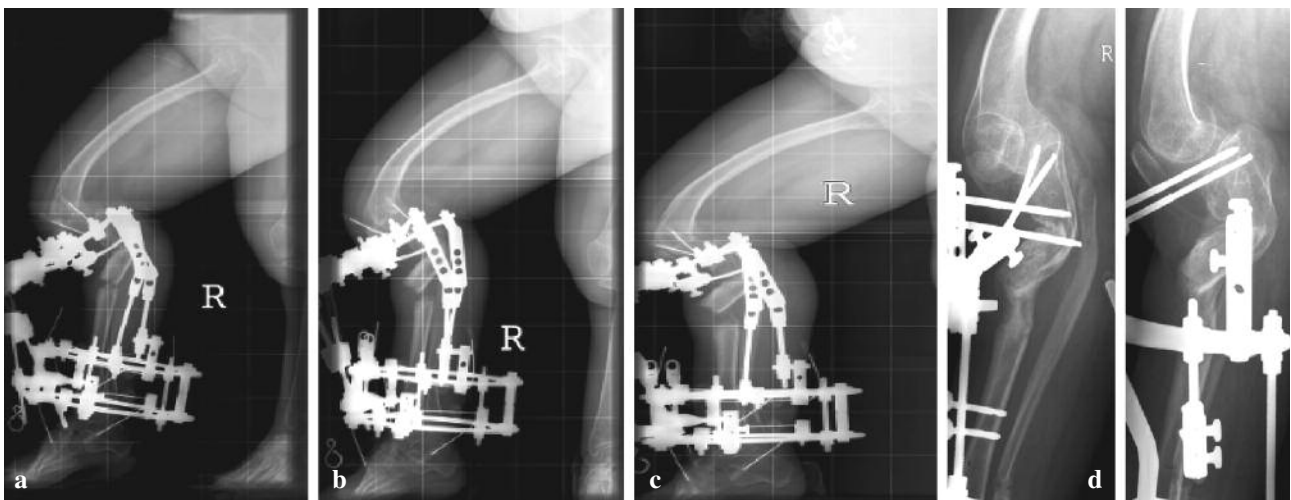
Radiographic image of the right leg at initiation of correction (a), after 2 weeks (b) and after 4 weeks of correction (c). Ten weeks later, the frame was reduced to a simple unilateral fixator (d).
